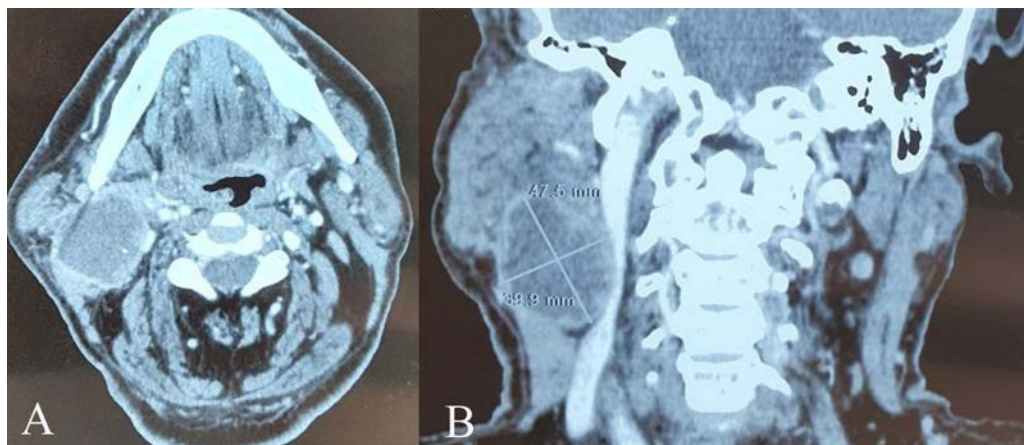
Computed tomography (CT) of the patient's neck with nodal metastatic disease in the neck with central necrosis: (A) axial view; (B) coronal view.
